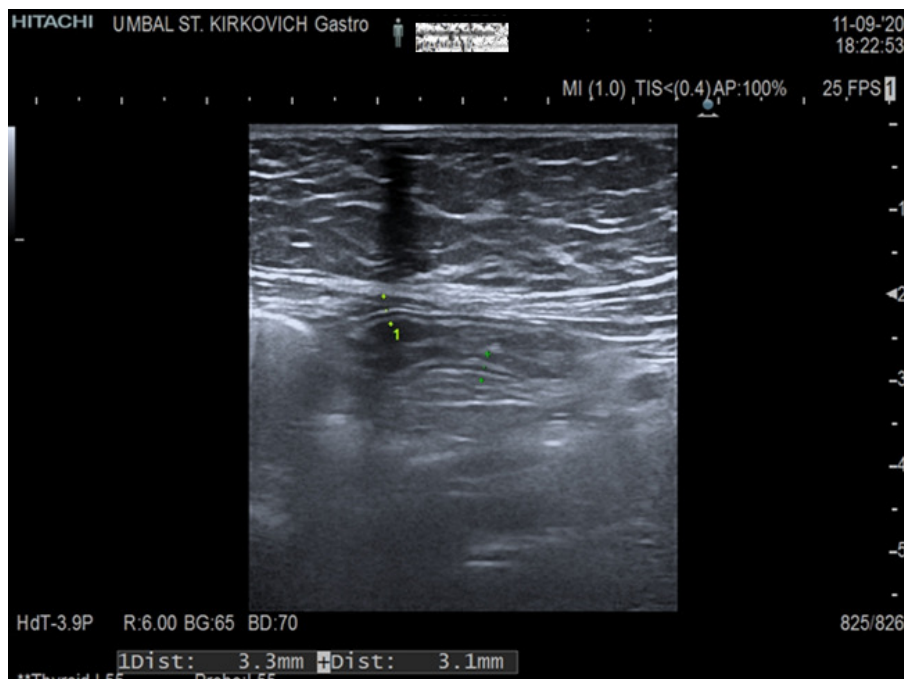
Abdominal ultrasound of patient number two.
